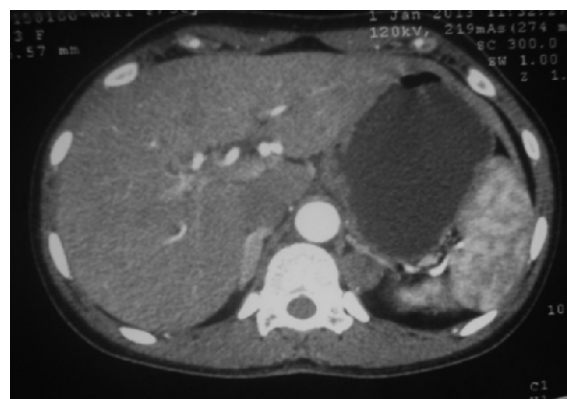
Contrast enhanced CT scan of the abdomen showing bilateral adrenal hyperplasia with a dominant nodule on the left side.
